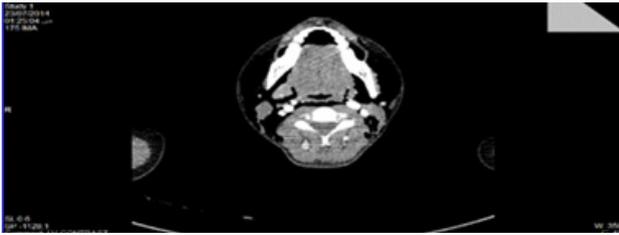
Thoracic CT showing diffuse soft tissues emphysema of the neck and skull base.
